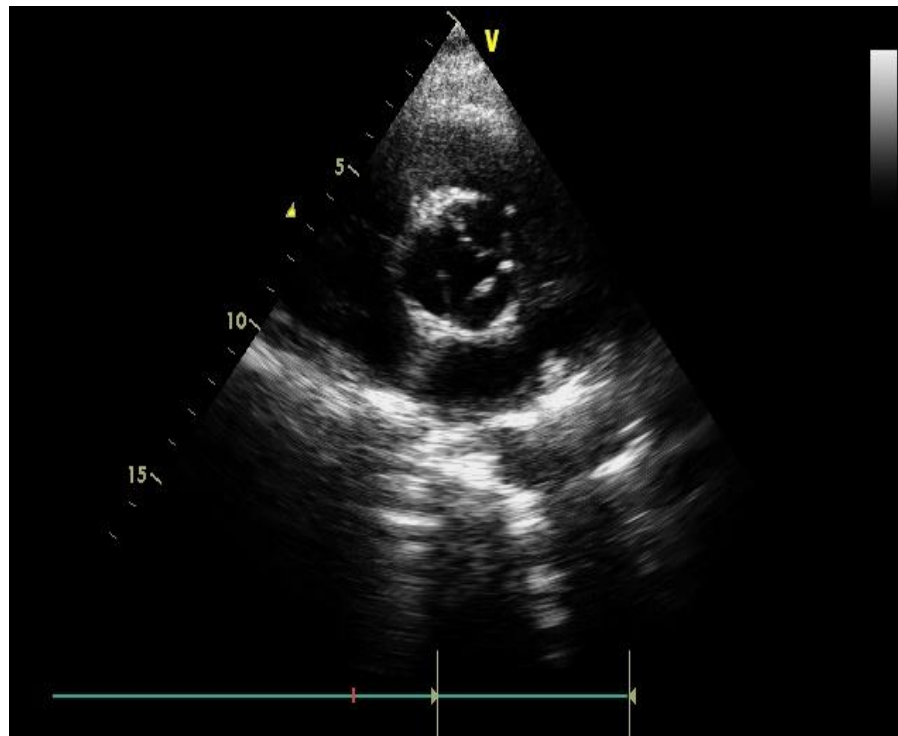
Parasternal short axis view showing tricuspid normal aortic valve
